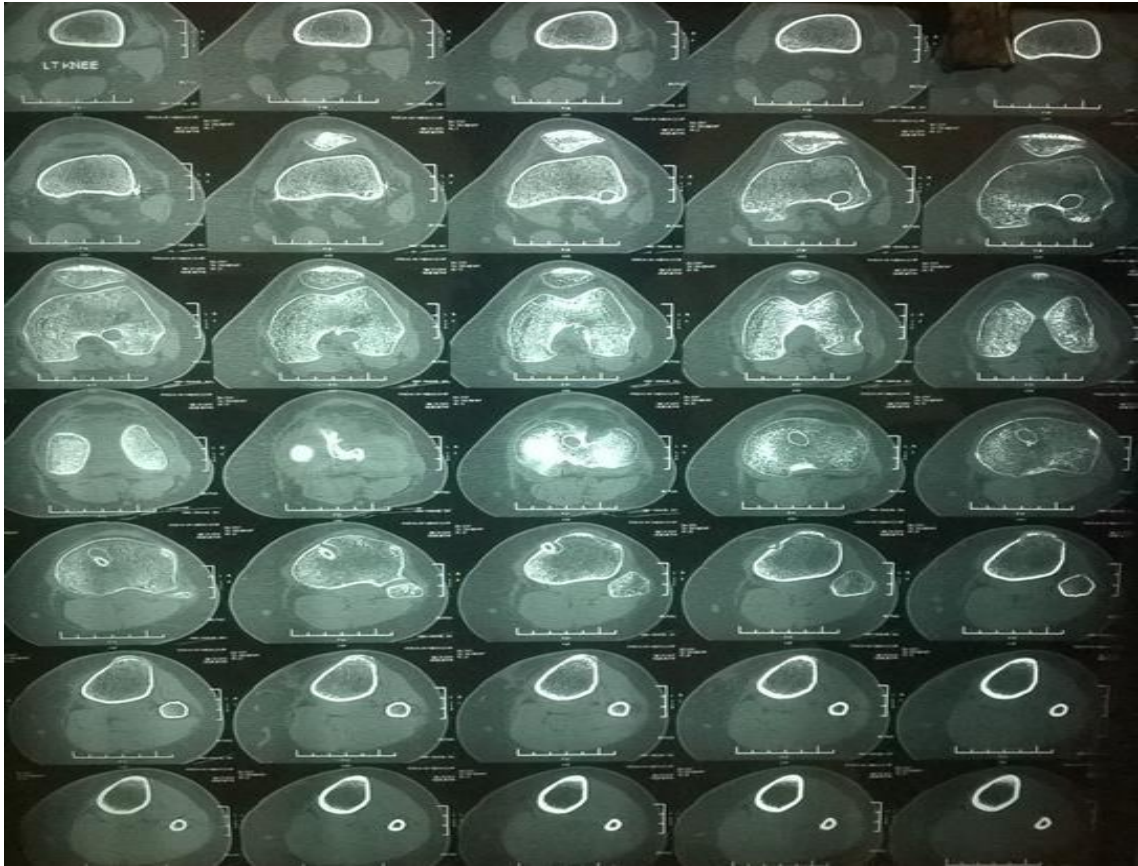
3D CT scan (post-operative) Case-1
